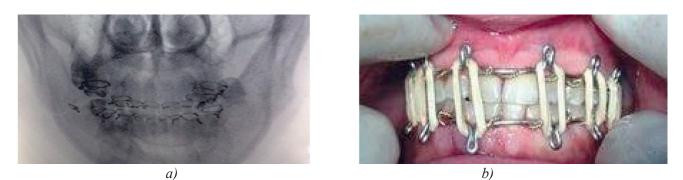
Reposition and fixation with bone suture. a) X-ray picture. b) Inter maxillary fixation
